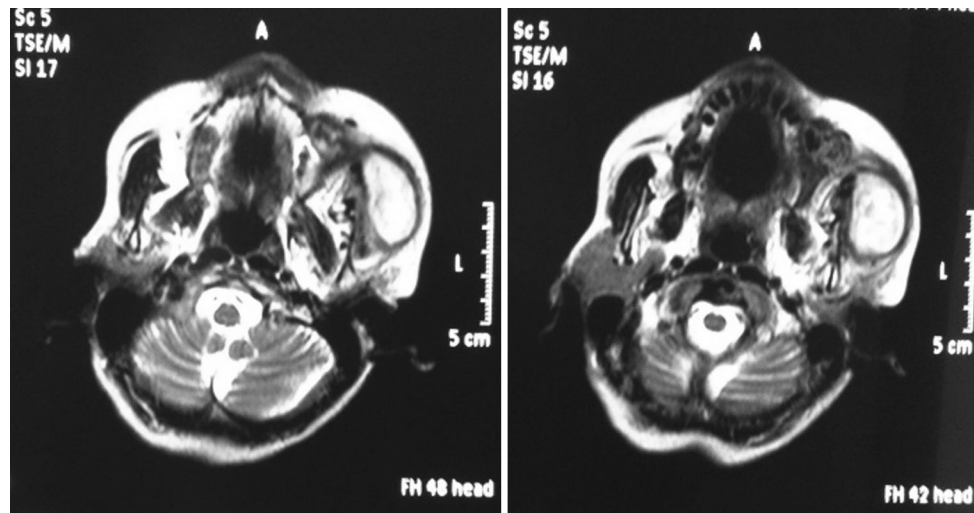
MRI images showed increased intensity in muscular mass of the left cheek
